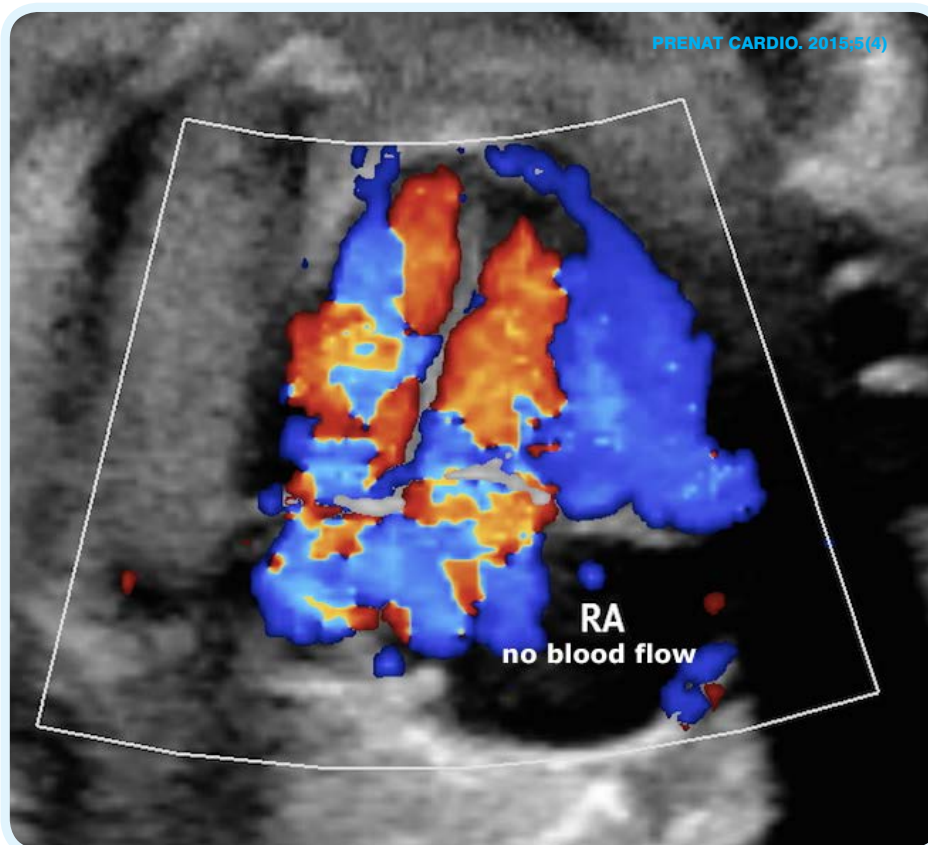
Prenatal echocardiogram. Diminished flow through right atrium
